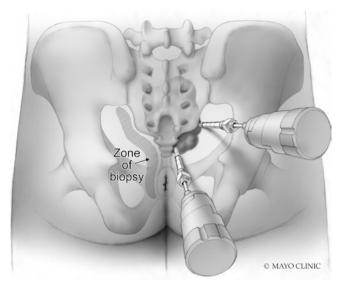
Preoperative biopsy technique using CT guidance. (Reused with permission of Mayo Foundation for Medical Education and Research, all rights reserved)
